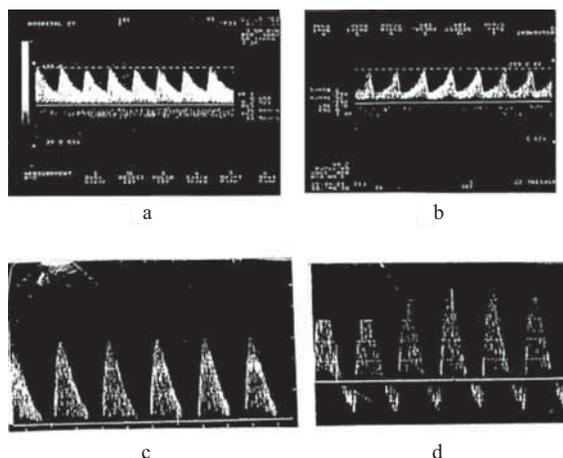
Dopplerometric indices of pregnant residents (III trimester): (a) healthy fetus; (b) initial stage of placenta insufficiency; (c) absence of diastolic component in all heart cycles; (d) reverse diastolic component of the blood flow in all heart cycles.
